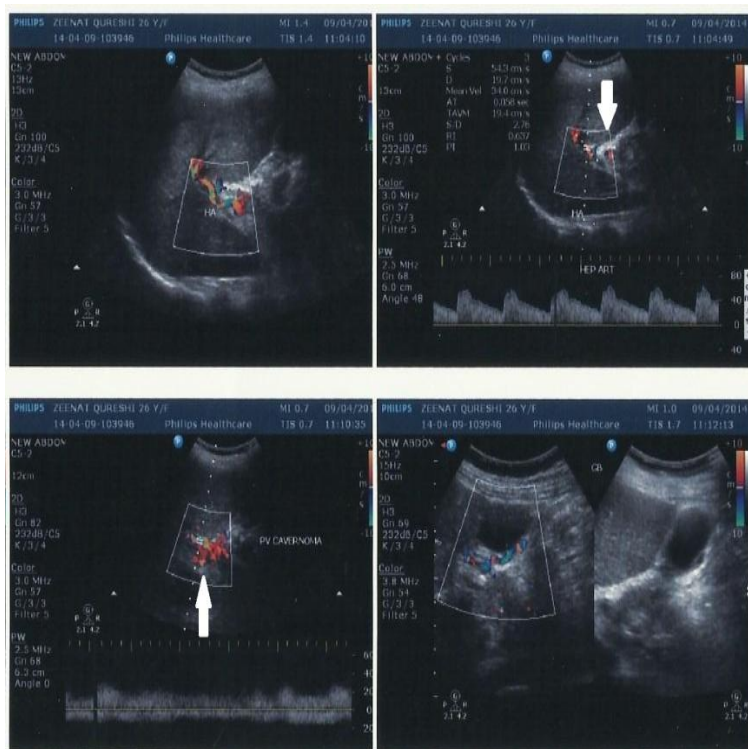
Colour Doppler of abdomen showing Portal and Splenic thrombosis (arrow)
